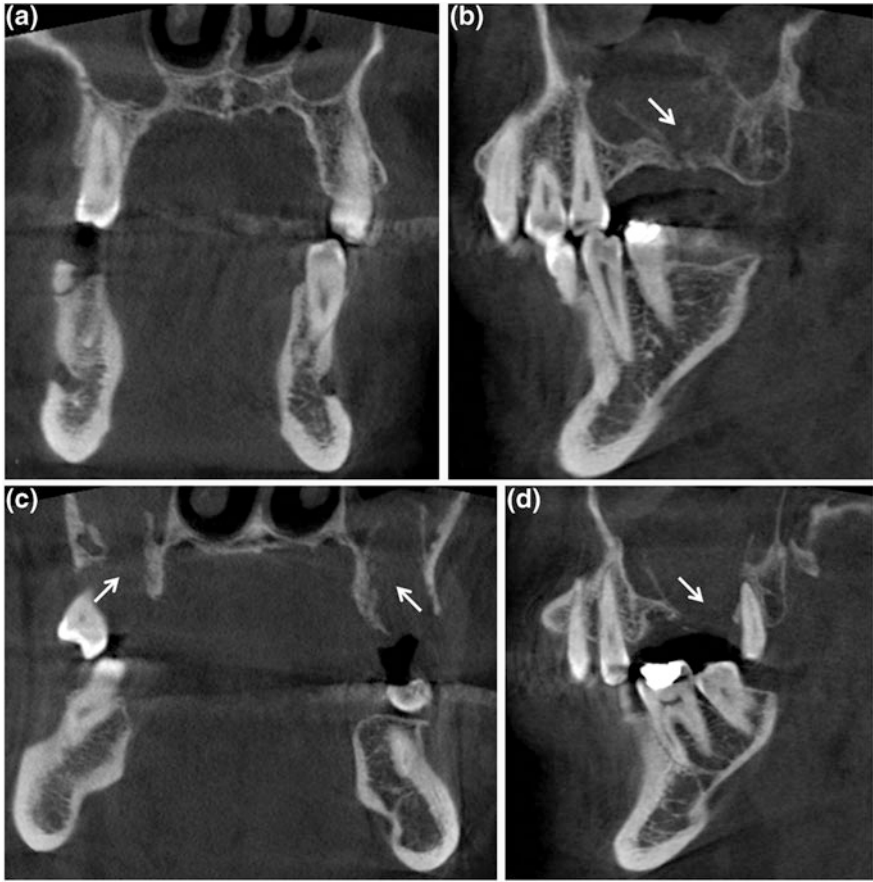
CBCT coronal (a), right and left sagittal (b, d) and axial (c) sections showing massive osteolysis of maxillary sinus floor in the molar region (*thin arrow*). Right and left maxillary sinuses were partially opacified
